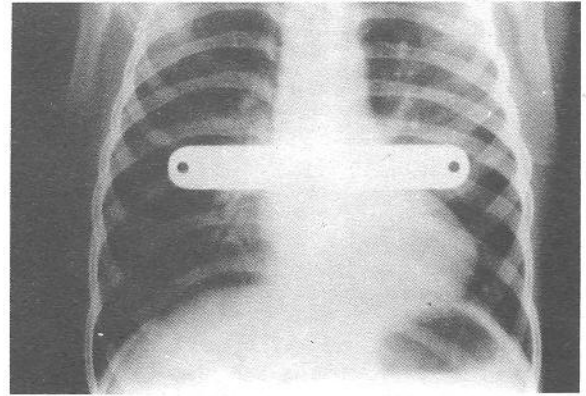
a). Postoperative posteroanterior, b) lateral roentgenograms 3 months after correction of pectus excavatum.
